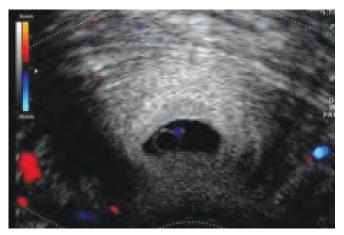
Transvaginal color Doppler scan of a cervical pregnancy. Note yolk sac and embryonic heart activity
